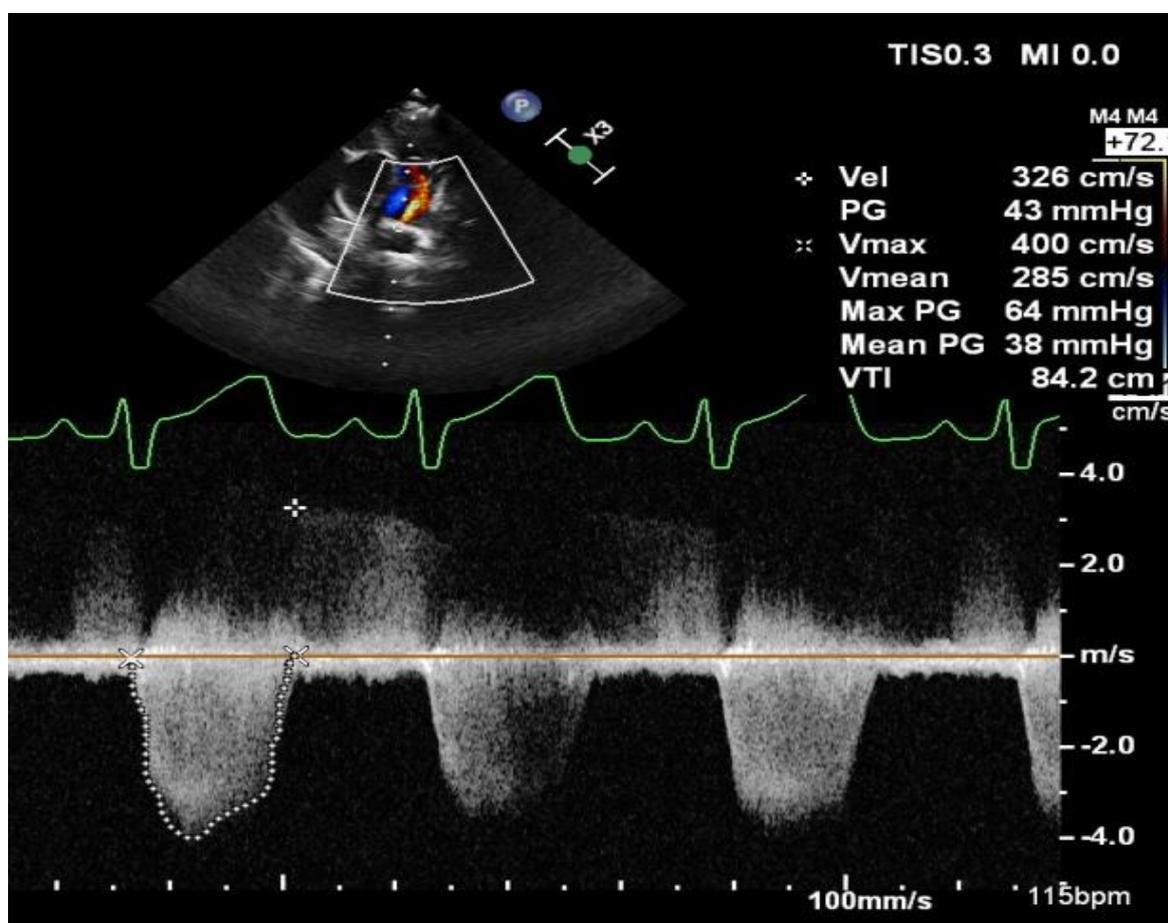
Continuous wave Doppler across right ventricular outflow showed significant gradient with the spectral wave pattern suggestive of valvular obstruction. Also the faint spectral wave of continuous flow across PDA was captured with significant pressure difference
